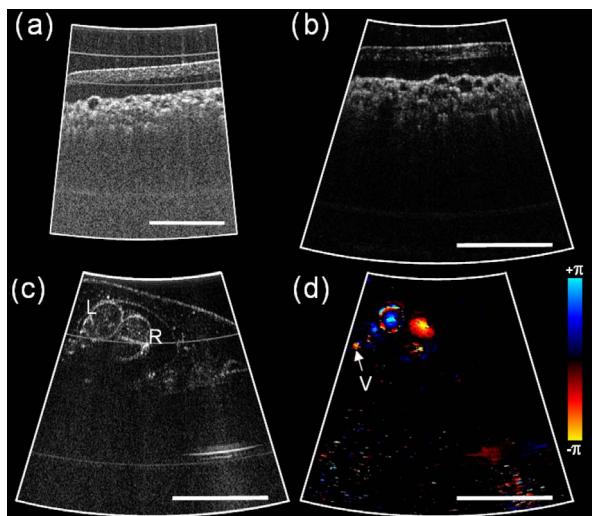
(Color online) (a) Sector image of an IR card taken using the electrostatic ball-lens probe, resulting in 13° scan angle. (b) Sector image of an IR card taken with an electrostatic probe in which the fiber was scanned behind a GRIN lens, demonstrating 33° scan angle. (c) Structural image of the heart of *Xenopus laevis* taken with the GRIN lens design identifies left (L) and right (R) aortic arches and (d) corresponding Doppler image showing the aortic branches. A small gill vessel is identified with a V. Horizontal scale bars, 1 mm. Scale corresponds to phase shift owing to Doppler effect.
